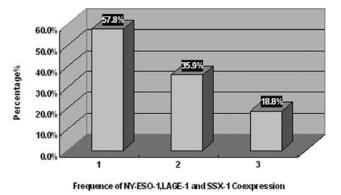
Co-expression of NY-ESO-1, LAGE-1 and SSX-1 in HCC. 1-3, number of co-expressed CT genes.
